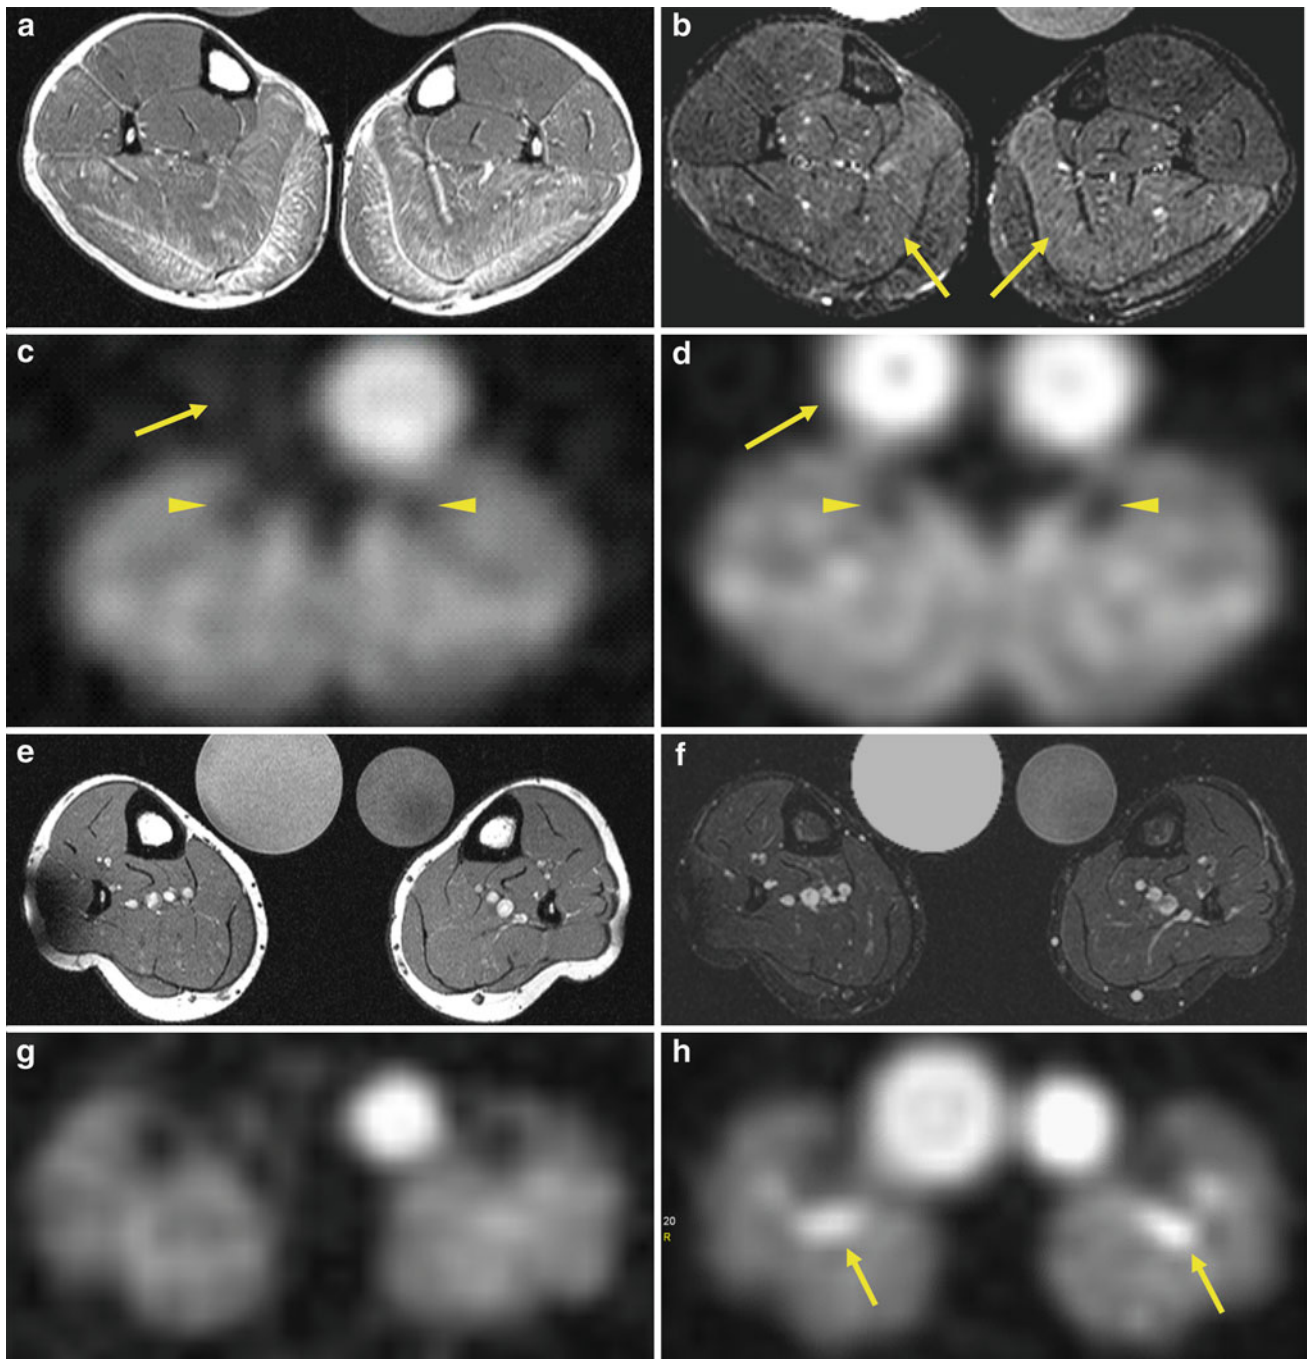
Edema-like changes and increased muscular sodium are present in Duchenne muscular dystrophy (DMD). MRI of both calves of a 10-year-old boy with DMD (a–d), a 16-year-old healthy volunteer (e–h), and a 22-year-old woman with DMD (i–l); a, e, i: T1-weighted, b, f, j: short tau inversion recovery (STIR), c, g, k: ^{23}Na inversion recovery (IR), and d, h, l: ^{23}Na tissue sodium concentration (TSC) images. There is fatty degeneration of the triceps surae muscles in the boy (a) and muscular edema of both soleus muscles (*arrows* in b) compared with normal findings in the volunteer (e–f). ^{23}Na IR (c) and TSC ^{23}Na MRI (d) reveal elevated signal in both soleus
